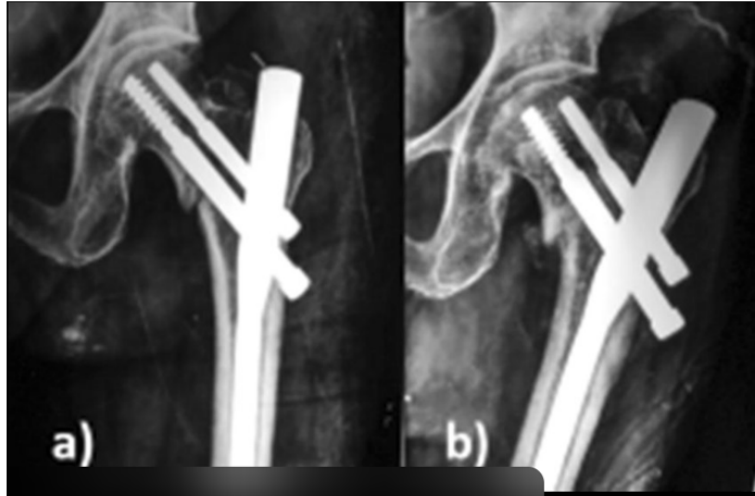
X-ray Showing an Intertrochanteric Fracture of the Femur in an Elderly Patient., Figure 1a: Post-Operative X-ray Showing Fixation with a Dynamic Hip Screw (DHS), Figure 1b: Post-Operative X-ray Showing Fixation with a Proximal Femoral Nail (PFN).
